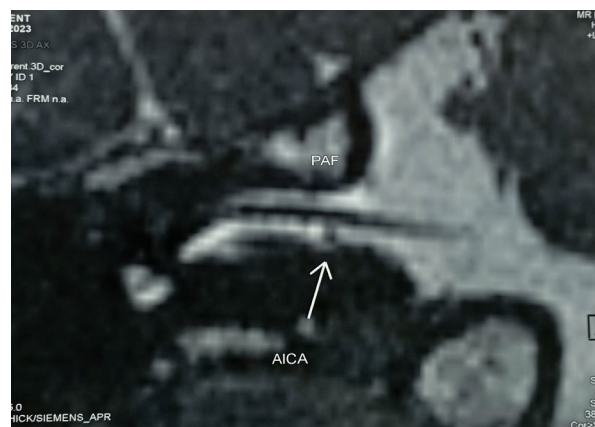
Coronal MRI section showing the right AICA loop and its configuration relative to the IAC, consistent with a type II lesion according to Chavda's classification.
